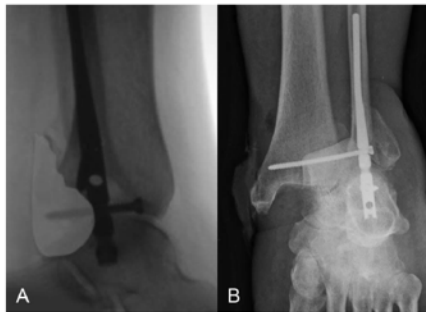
Anteroposterior radiograph from a 56-year-old patient who was allowed to fully weight-bear after surgery, despite recognized syndesmotic injury, demonstrating loosening of the PLS and a diastasis seen 4 weeks postoperatively (A). Final radiograph 2 years after revision surgery with deeper nail implantation, an additional PLS and non-weight-bearing restrictions for 8 weeks postoperatively (B).
